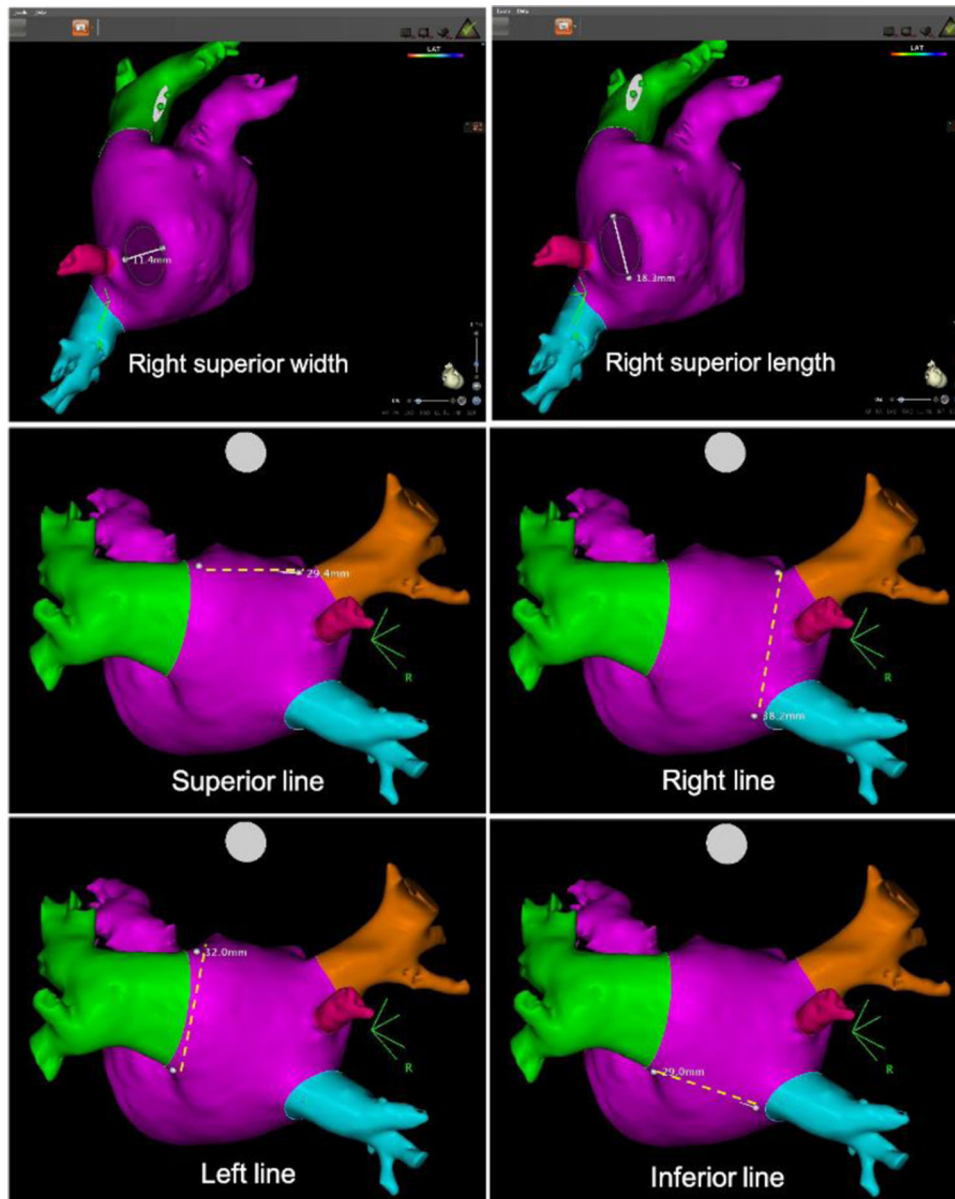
An example of the measurement technique on the CT images of the same patient shown in Figure 1. Measurements were performed using a 3D image on the CARTO auto-segmentation module. Anatomy demonstrated a LCPV and a separate right middle PV. Upper panel: RSPV length and width diameters measured at an approximately 90° angle. Middle and lower panel: Posterior wall line measurements are shown (white dashed lines), the measurement points were placed sequentially (white dots), while leaving the last point in the same location when measuring the next line, hence using the exact same points for all the lines. CT, computed tomography; LCPV, left common pulmonary vein; PV, pulmonary vein; RSPV, right superior PV
